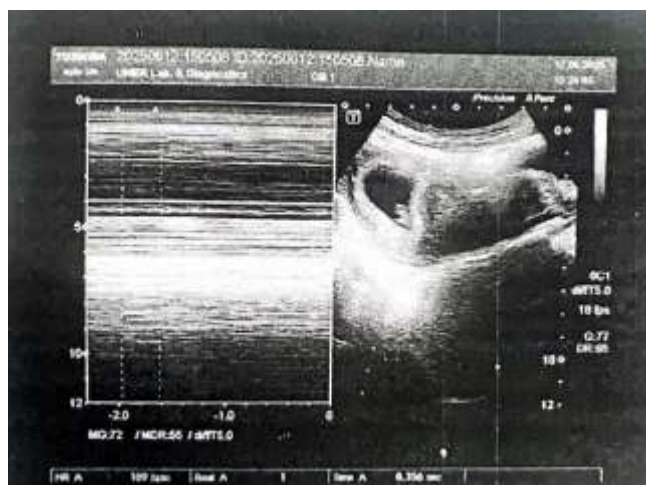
Transvaginal ultrasound scan showing a viable early intrauterine pregnancy. The B mode image (right) displays a gestational sac with a fetal pole, while the M-mode trace (left) confirms fetal cardiac activity with a heart rate of 131 bpm. Scan performed on 17 January 2025 using Toshiba Apllo 500 at UMER Lab & Diagnostics.
